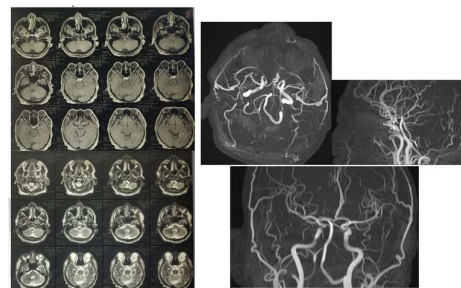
From the MRI examination, there are no hypointense/hyperintense lesions in the brain parenchyme, which with contrast administration did not show abnormal contrast enhancement
